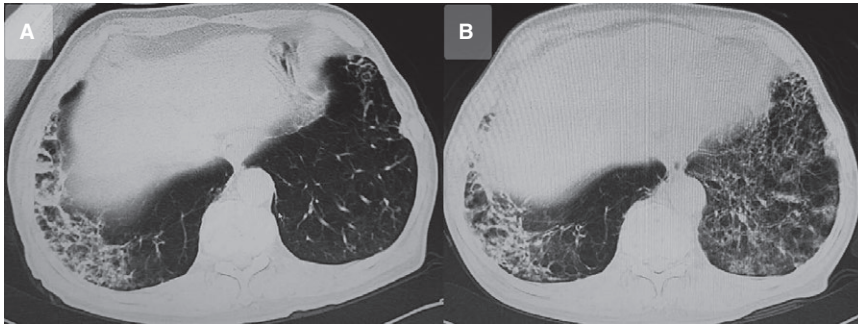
Chest computed tomography without contrast on admission. Chest computed tomography (CT) without contrast on admission revealed ground-glass opacity (GGO) in right lung (A). Bilateral pulmonary GGO suggestive of interstitial pneumonia was noted on chest CT on referral (B)
